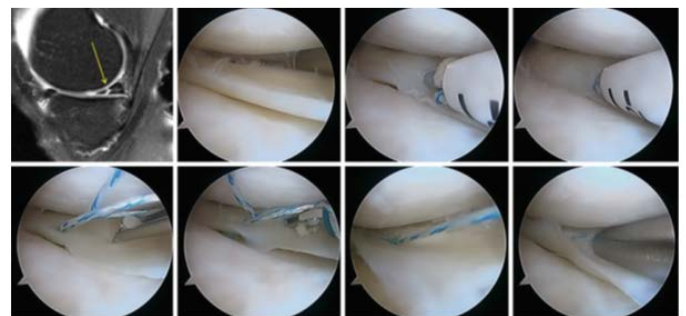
MRI of longitudinal tear and arthroscopic view, all-inside repair sequence with the first anchor
